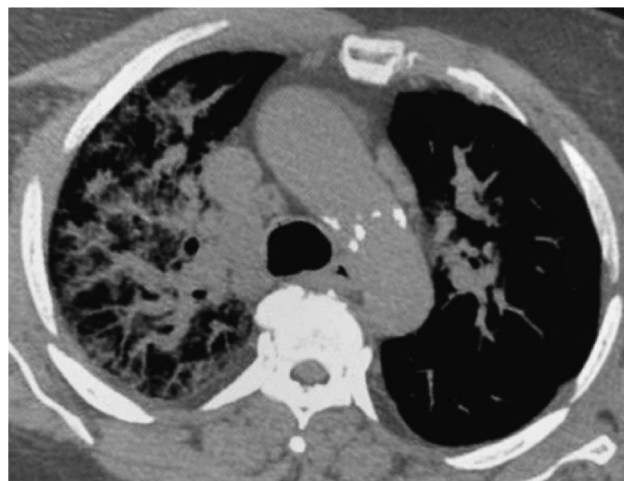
Chest computed tomography of patient on March 16, 2020, showing extensive right lung infiltrates.
